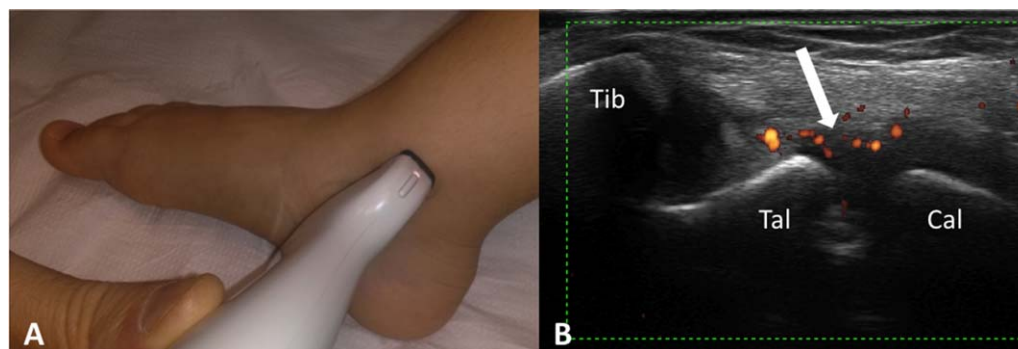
Position of the probe for the medial scanning approach to the subtalar joint (A) and synovitis (arrow) (B) exhibiting power Doppler signal through the medial scanning approach in a 13-year-old girl with juvenile idiopathic arthritis. Tib = tibia; Tal = talus; Cal = calcaneus.
